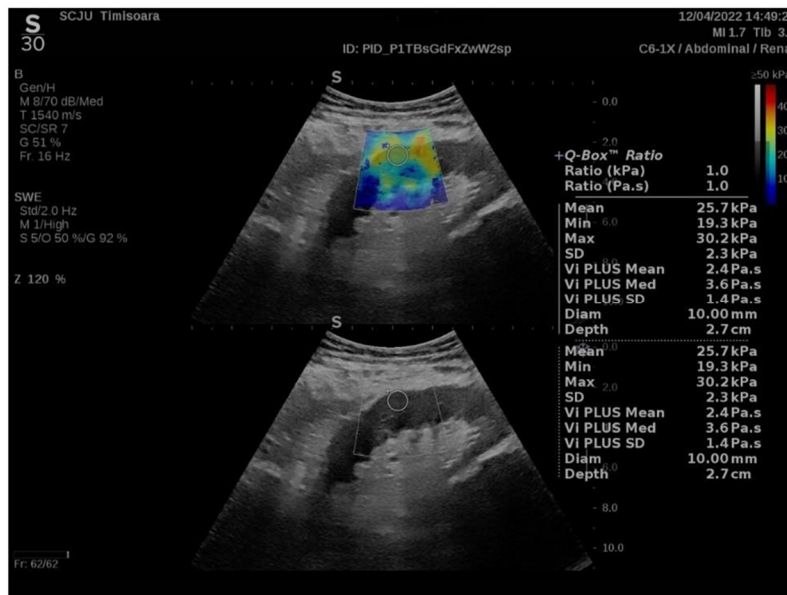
Viscoelasticity of tissue, expressed in Pa.s, obtained using the Hologic Aixplorer Mach 30 ultrasound system
